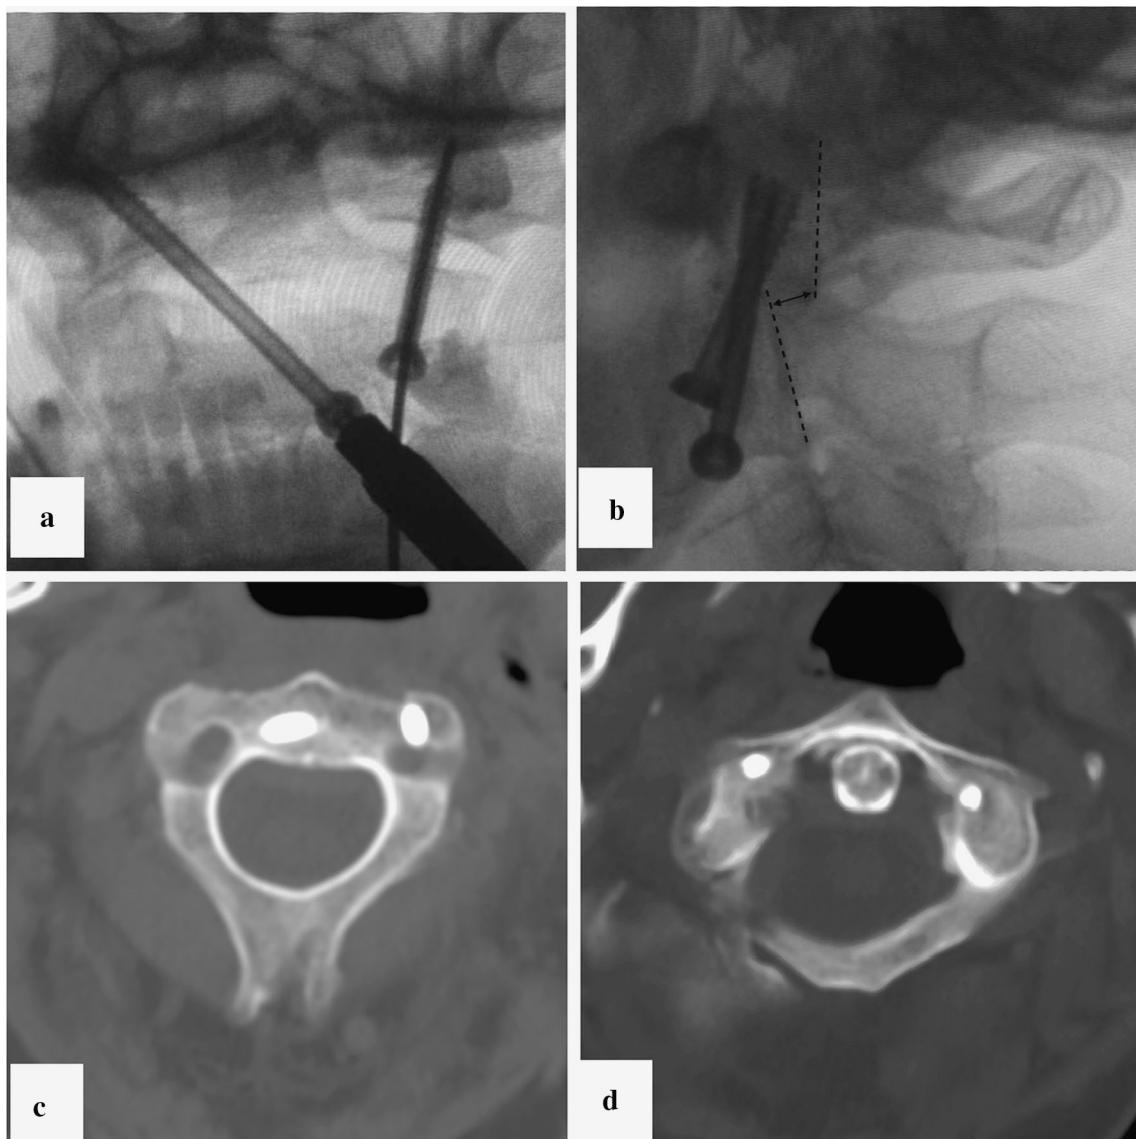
Case 2: post-operative X-ray images and CT scans. a Control X-ray in the transoral plane. b Control X-ray in the lateral plane. We continued to observe dorsal dislocation of the atlantoaxial complex by
